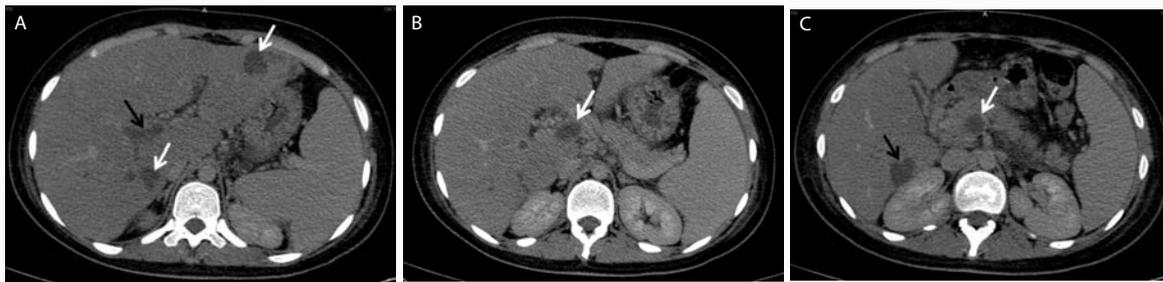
A: Hepatic abscess with portal vein thrombosis in a 16-year-old girl. Contrast-enhanced CT scan shows hypoattenuating abscesses (white arrows) with a linear, hypoattenuating branching structure (black arrow), representing a thrombosis in the right portal vein. B: Note the hypoattenuating thrombosis in the main portal vein (arrow). C: Contrast-enhanced CT scan demonstrates hypoattenuating thrombosis in the superior mesenteric vein (white arrow) and hypoattenuating abscess in the segment VI (black arrow).
